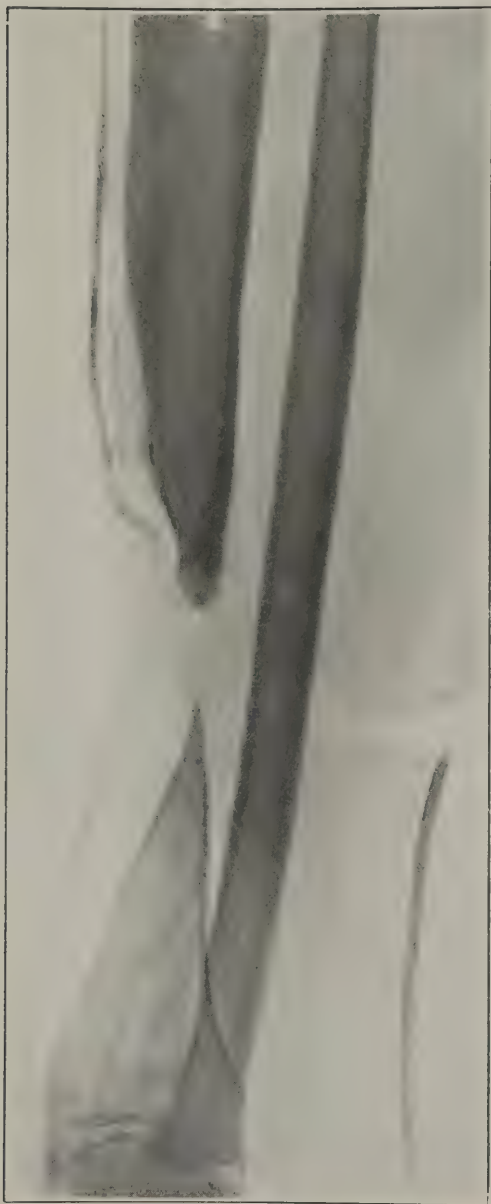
Case 12. Roentgenogram showing loss of substance
